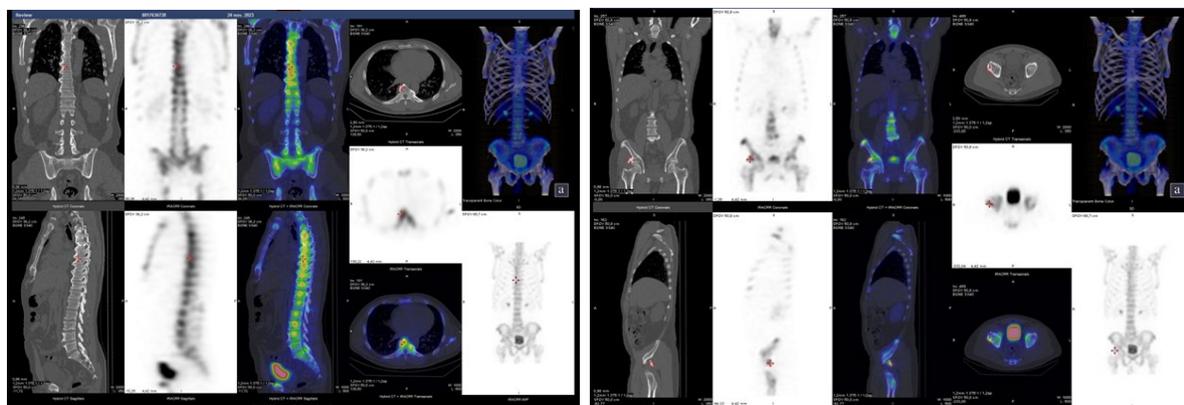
SPECT/CT acquisitions suggestive of DISH: multi-staged thoracic intervertebral osteophytic bridges lateralized to the right and multiple ossifications of the ischial entheses and anterosuperior iliac spines.
